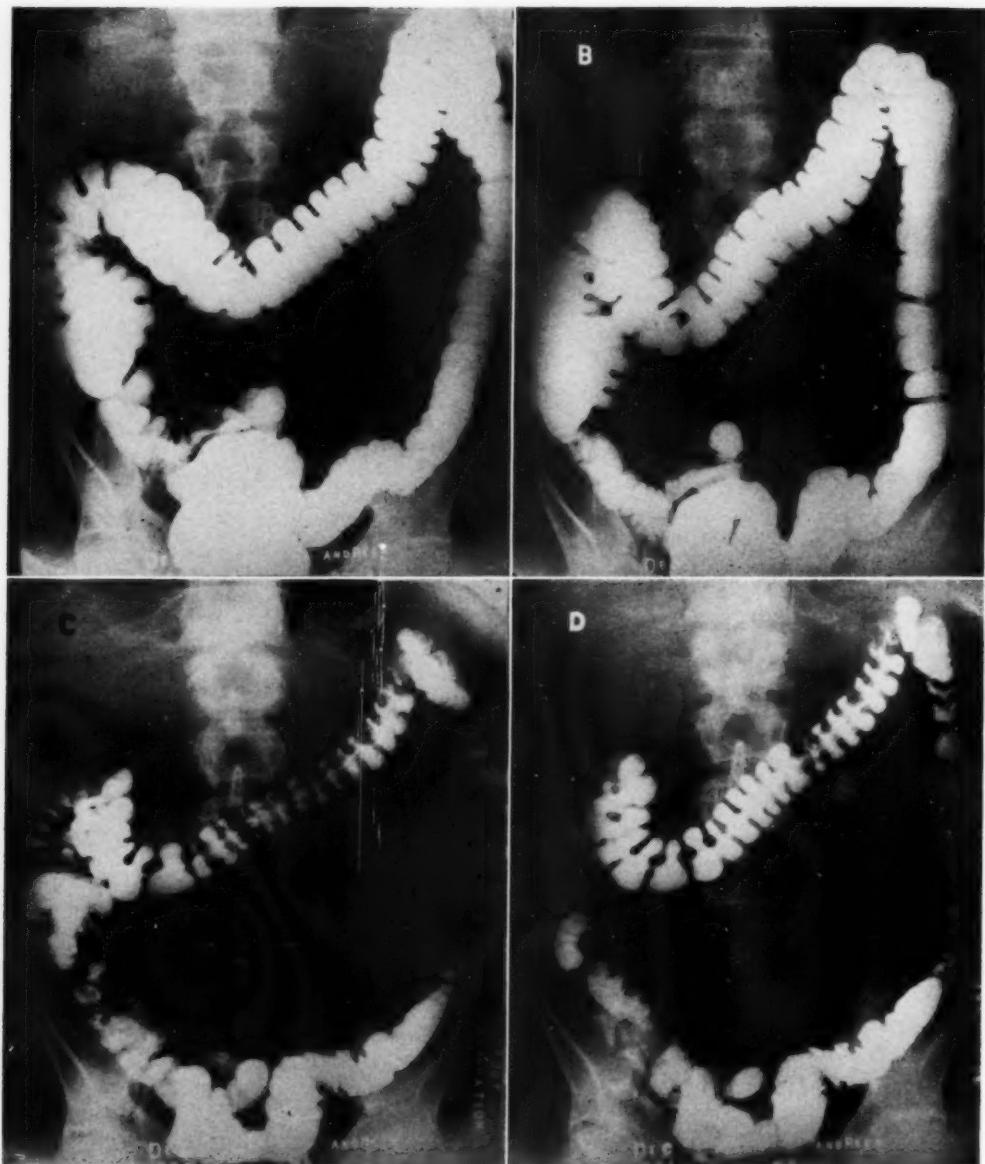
C and D. Case 3. Fig. 5A and B are roentgenograms of the colon after a barium enema study to show non-visualization of the outer portion of the descending colon without flank compression and visualization of the missing part of the colon after flank compression. Fig. 5C and D are roentgenograms of the same case after evacuation of the barium enema. Even after evacuation, it was not possible to depict the entire colon on the one 14 X 17-inch film without flank compression. Fig. 5D shows visualization of the entire colon after flank compression.
